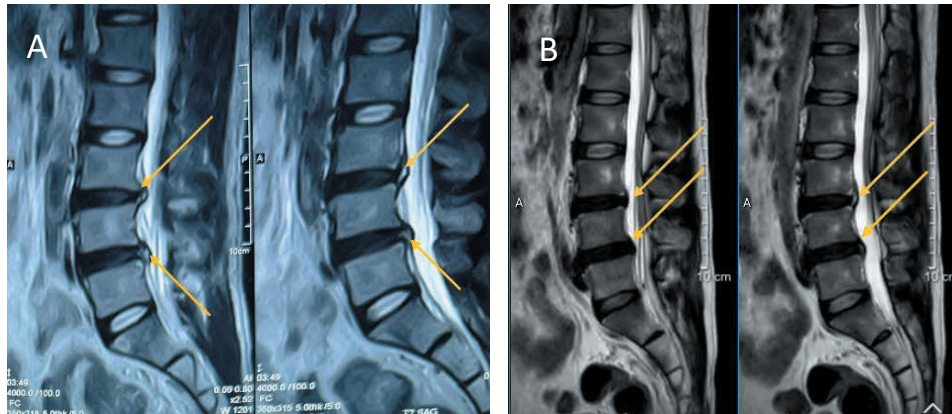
A: MRI images of the lumbar spine before intervention.
